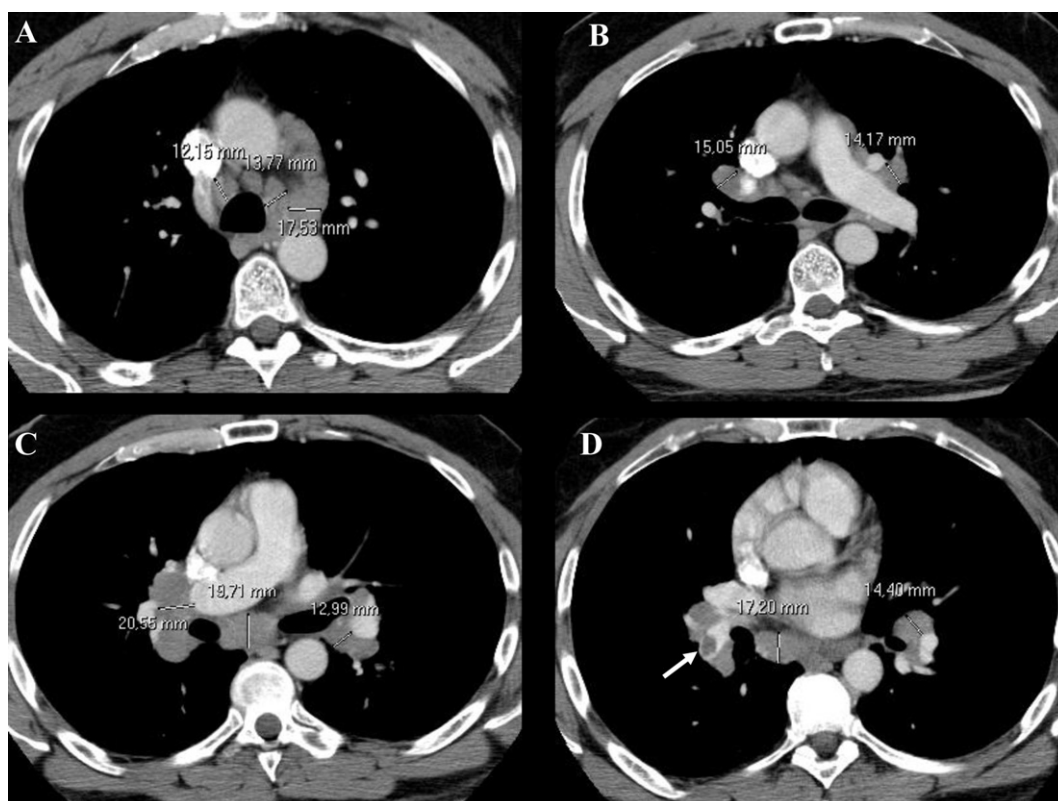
Contrast-enhanced CT of the chest (axial view) from a 52-yr-old male sarcoidosis patient. Enlarged lymph nodes are seen in stations (A) #4R (12.15 mm), #4L (13.77 mm), #5 (17.53 mm); (B) #10R (15.05 mm), #12L (14.17 mm); (C) #11R (20.55 mm), #7 (19.71 mm), #11L (12.99 mm); (D) #8R (17.20 mm), #12L (14.40 mm). An intravascular filling defect consistent with an embolus was found, as an incidental finding, in the pulmonary artery for right lower lobe (panel D, arrow).
